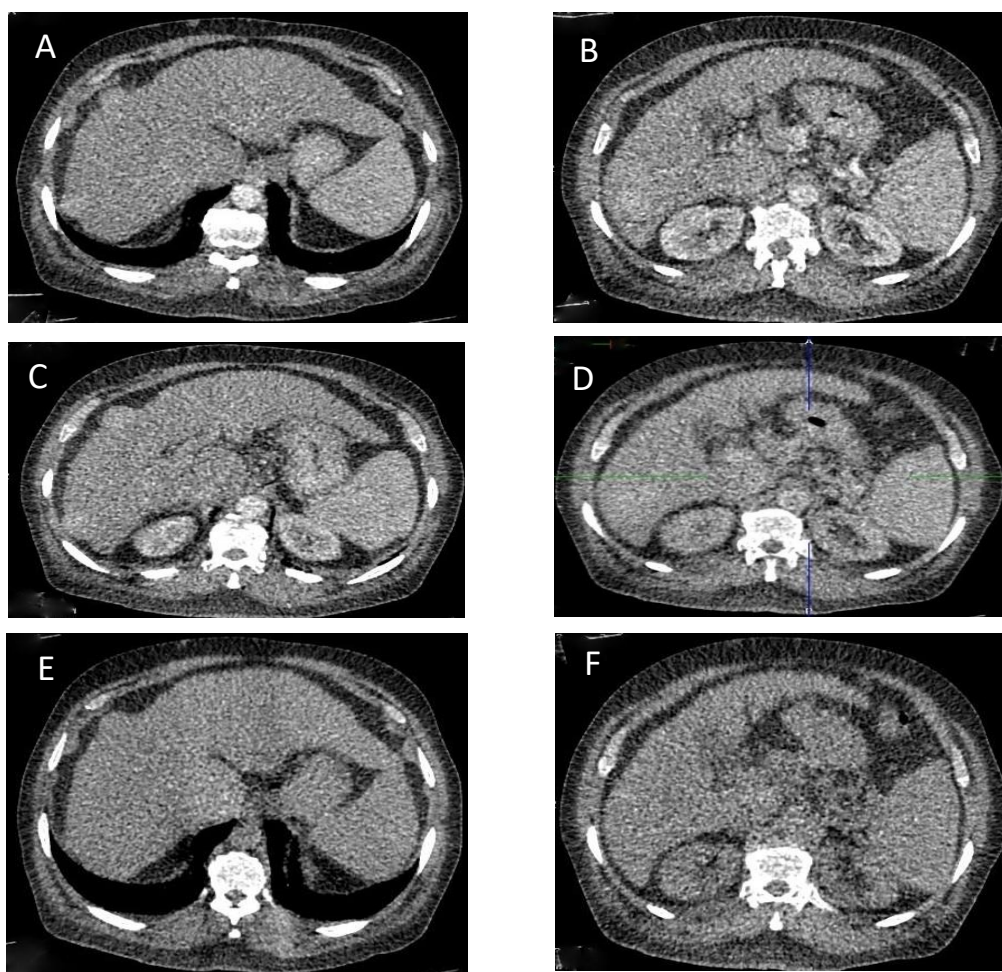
Triphasic CT shows: (A & B) two different levels of the liver in arterial phase showing two, right hepatic lobe, early enhancing focal lesions being subcapsular and segment V ill defined area of heterogenous enhancement, (C & D) the same levels in porto-venous phase showing rather same enhancement of the subcapsular lesions with washout of contrast at the segment V one, (E & F) the delayed phase with washout of contrast in all lesions.
